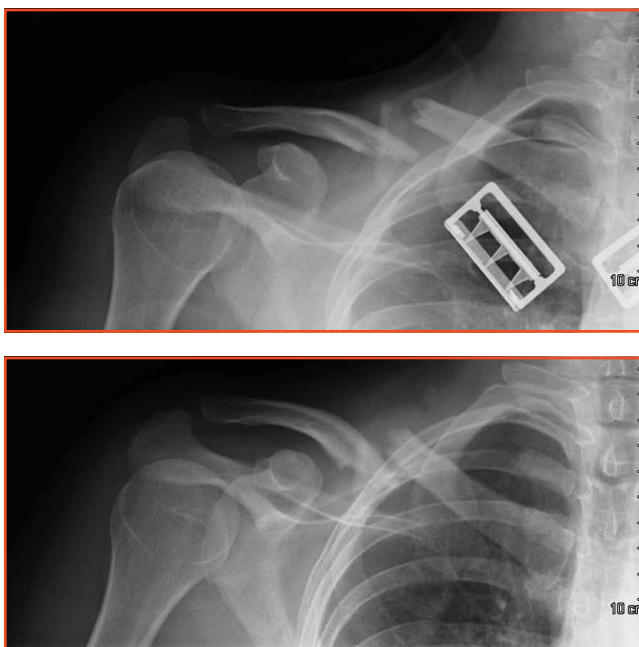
Case 2: Radiographs showing fracture of right clavicle.
